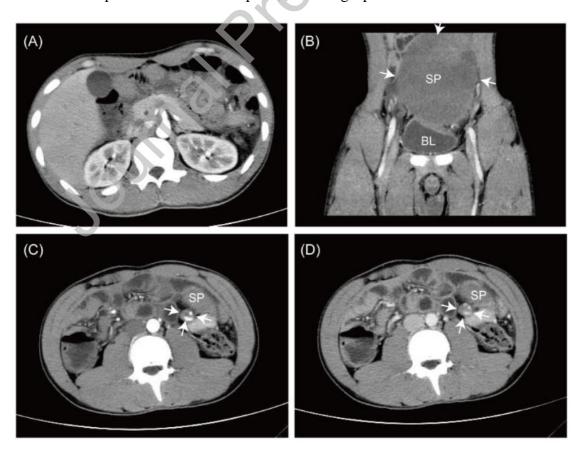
Contrast-enhanced computed tomography images of a wandering spleen
